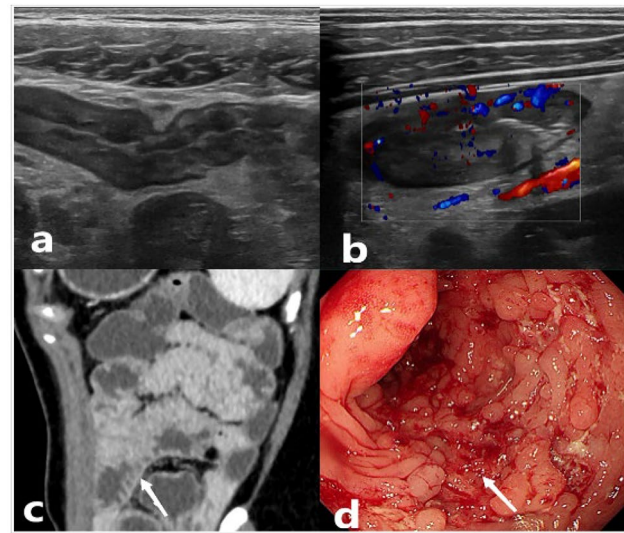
IUS, CTE, and endoscopic results in a representative Crohn's disease patient. A 22-year-old male was diagnosed as A2L3B2 according to the Montreal classification. a: IUS shows thickening and loss of stratification of the terminal ileal wall; b: Color Doppler imaging reveals that the terminal ileum has full blood flow signals with a score of 3; c: CTE reveals multiple diffuse intestinal wall thickening with comb-like features; d: Colonoscopy finds extensive ileocecal mucosal ulceration and typical lithoid hyperplasia
